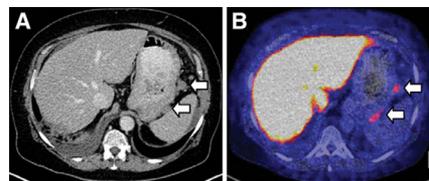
Metastatic ovarian cancer. Transaxial CT (A) and FES-PET/CT (B) images of a patient with focally increased FES uptake in the metastatic lesions between the stomach and spleen (arrows). Reprinted with permission.¹⁰
